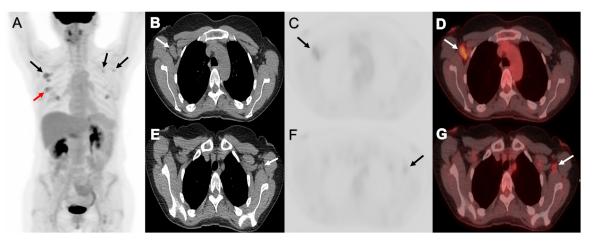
49-year-old female patient with right breast cancer underwent baseline PET/CT scan for staging. PET maximum intensity projection (MIP) images (A,C,F) and axial PET/CT fusion images (D,G) shows hypermetabolic right breast malignant mass (red arrow), enlarged hypermetabolic biopsy-proven metastatic right axillary adenopathy (SUV max of 3.3) and faint FDG uptake in COVID-19 vaccine-related reactive sub-centimeter left axillary and sub-pectoral lymph nodes (SUV max of 1.8) 3 months after left arm vaccine injection (black and white arrows). (Color version of figure is available online.)
